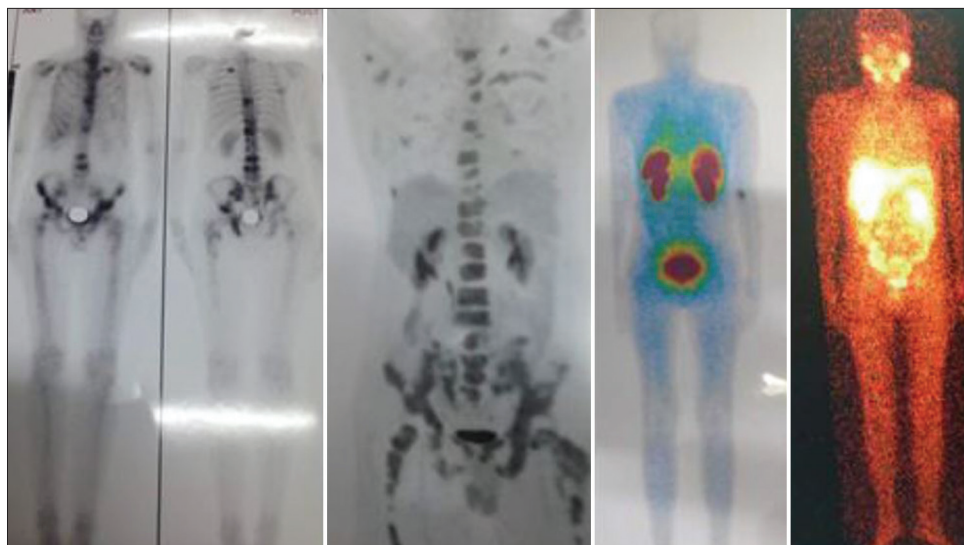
A 44-year-old man with carcinoma of unknown primary. The bone ^{99m}Tc-methylene diphosphonate scintigraphy demonstrated several skeletal lesions throughout the body, ^{99m}Tc-prostate-specific membrane antigen scintigraphy and ¹⁸F-fluorodeoxyglucose positron emission tomography images showed avid lesions only in the pelvis, and ^{99m}Tc-octreotide scintigraphy demonstrated no activity, highlighting the intertumoral heterogeneity
